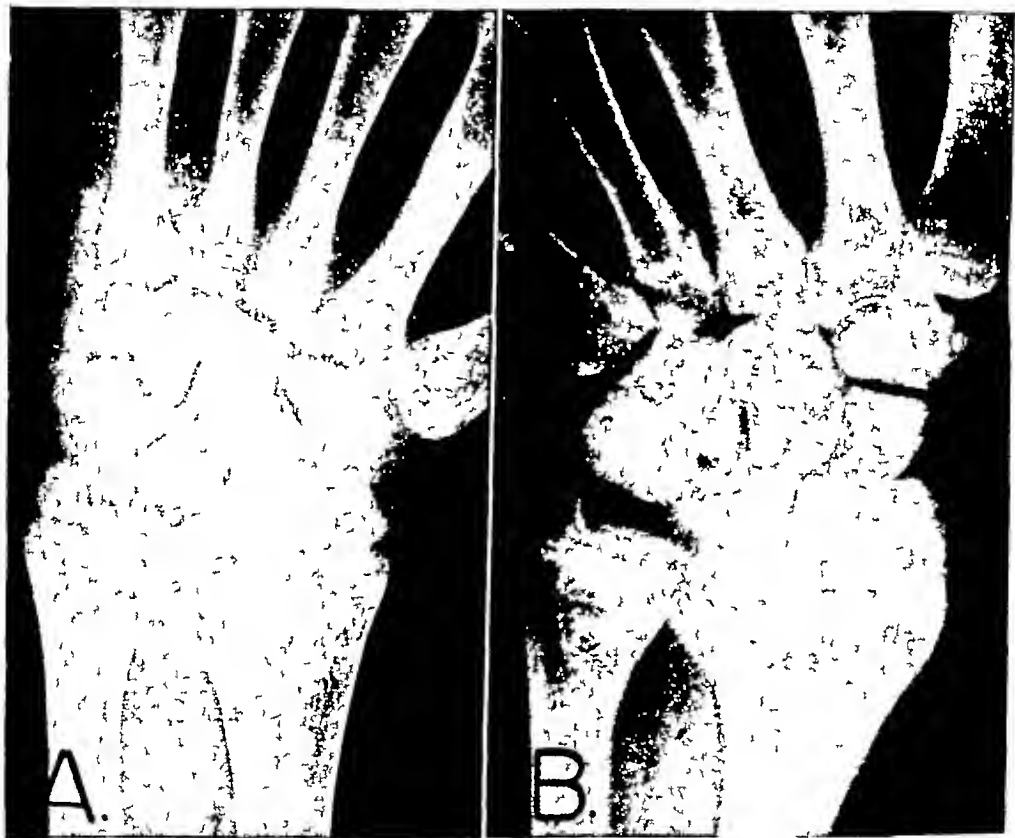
X-RAYS OF WRIST ON CASE 5 WITH RICKETS RESULTING FROM RENAL ACIDOSIS (A) BEFORE (1-10-39) AND (B) AFTER (2-24-39) HEALING OF RICKETS WITH MASSIVE DOSES OF VITAMIN D
